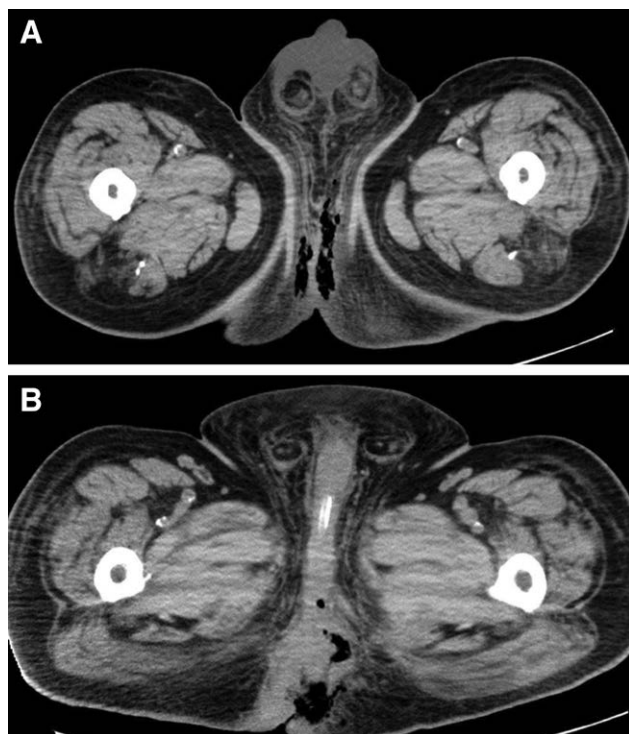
CT scan findings. Gas gangrene from the posterior part of the scrotum was shown (A). It reached around the entire circumference of the anus (B).
